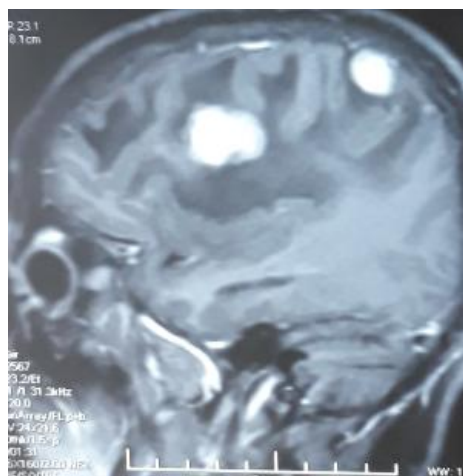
MRI Brain showing multiple brain metastasis
